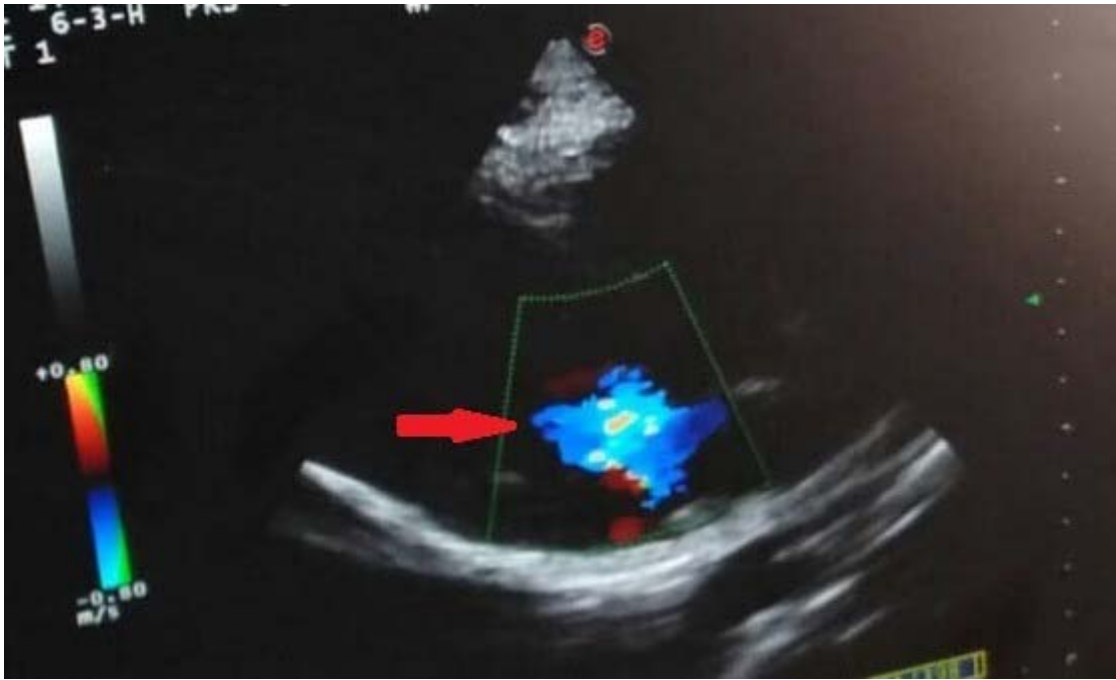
Echocardiography showed pericardial effusion in the left ventricle posterior and increase in pericardial brightness
